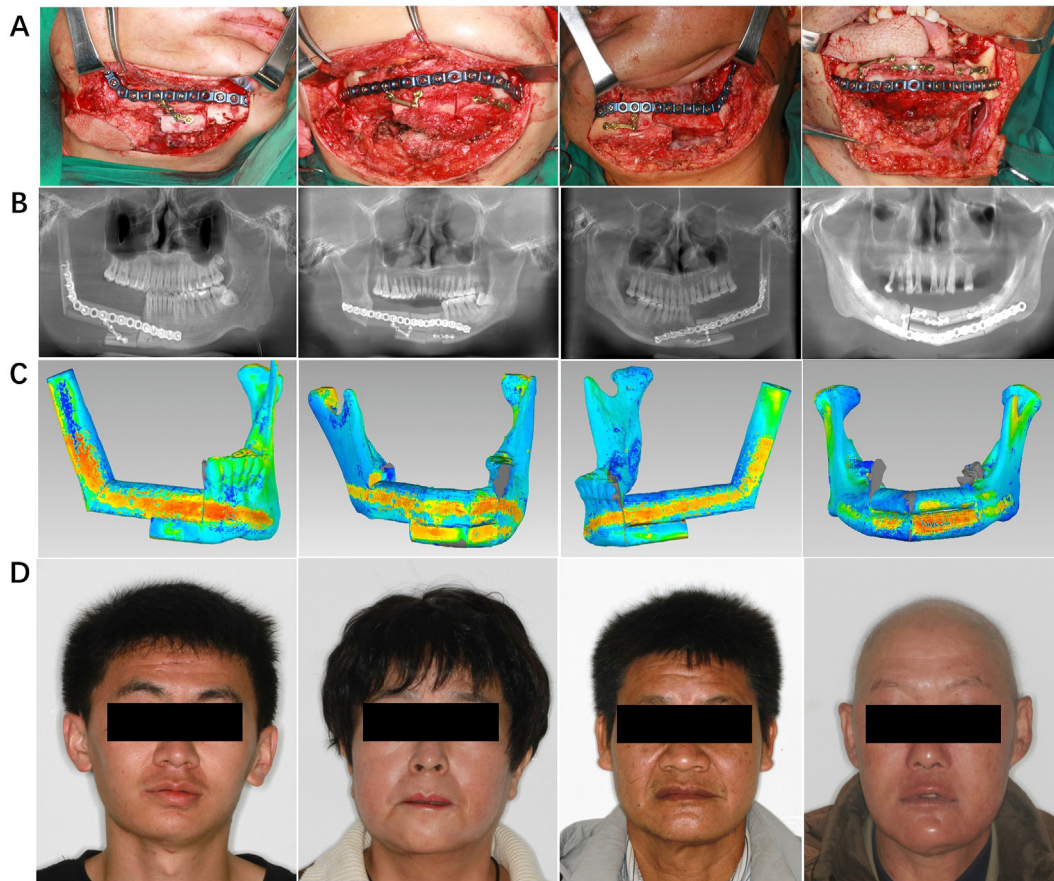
Example of class Ic-III reconstruction after ablation. (A) The proper fibular segments were transferred to reconstruct the defect. (B) Postoperative orthopantomograms for class Ic-III mandibular defects. (C) Color-coded discrepancy map of reconstruction mandible with the double-barrel vascularized free fibula flap. (D) Frontal images of the patient after surgery.
